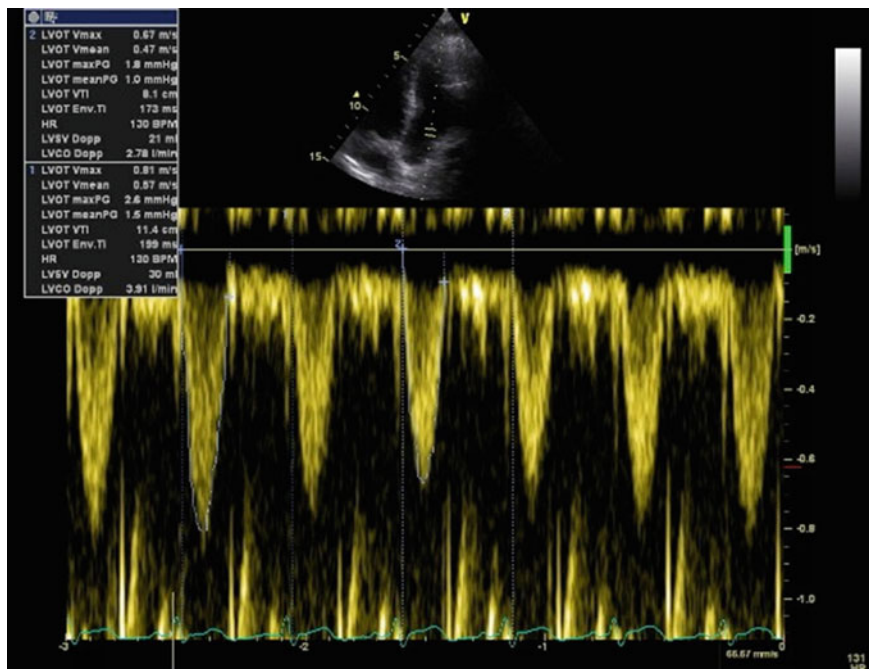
Doppler trace of the left ventricular outflow tract (LVOT) demonstrating the change in blood flow with respiration in a ventilated fluid responsive patient
